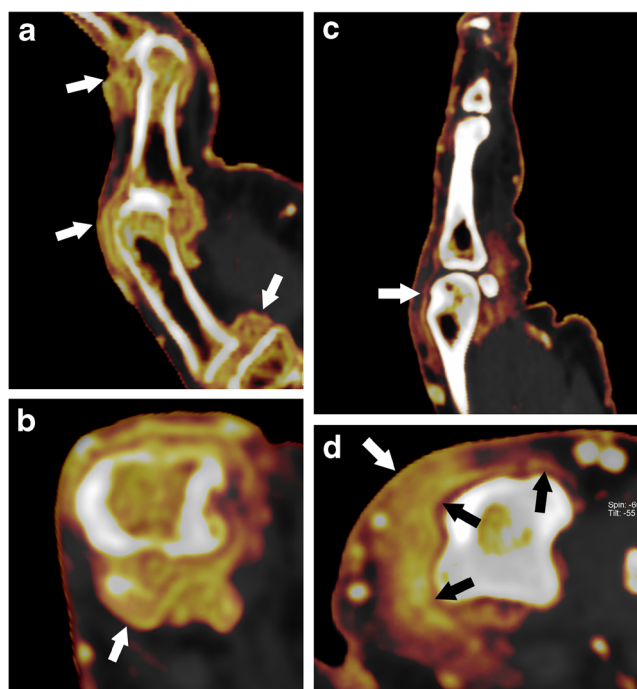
Synovitis in a 69-year-old patient with rheumatoid arthritis (RA) (a, b) and a 43-year-old patient with psoriatic arthritis (PsA) (c, d). (a) Sagittal dual-energy computed tomography (DECT) iodine map of the first finger shows enhancement of florid proliferative synovium, suggesting pannus formation in multiple joints (arrow). (b) Both inflamed synovium and pannus are apparent in the transverse metacarpophalangeal (MCP) joint image (arrow). (c) Sagittal image showing linear enhancement along the joint capsule (arrow). (d) Extra-articular inflammation is more prominent in the transverse image (arrow). Linear joint capsule enhancement suggests inflamed synovium (black arrow). Subcutaneous dot and tubular structures of enhancement are reflecting subcutaneous vessels. Normal skin also appears as a thin bright layer
